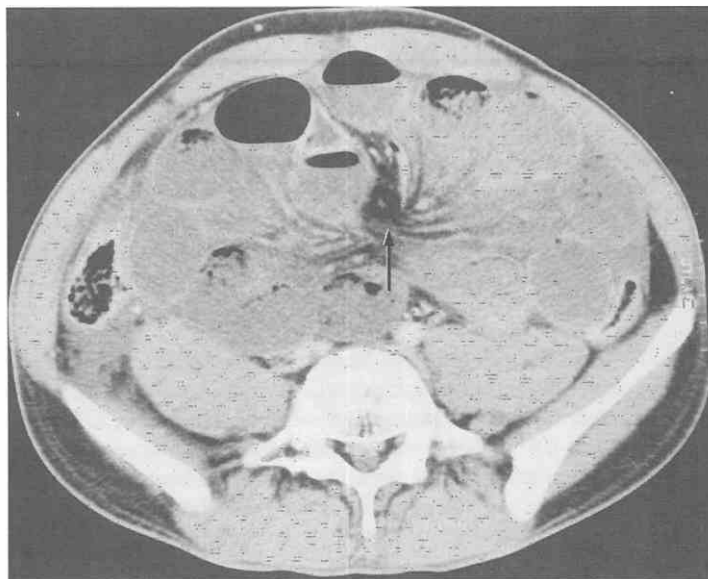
Closed-loop obstruction caused by volvulus. CT scan shows convergence (arrow) and engorgement of the mesenteric vessels. Small-intestinal loops are poorly enhanced compared with the colonic loops. Intestinal strangulation was confirmed at surgery. (From Ha HK, Kim HS, Lee MS, et al: Differentiation of simple and strangulated small bowel obstructions: Usefulness of known CT criteria. *Radiology* 204:507-512, 1997.)
